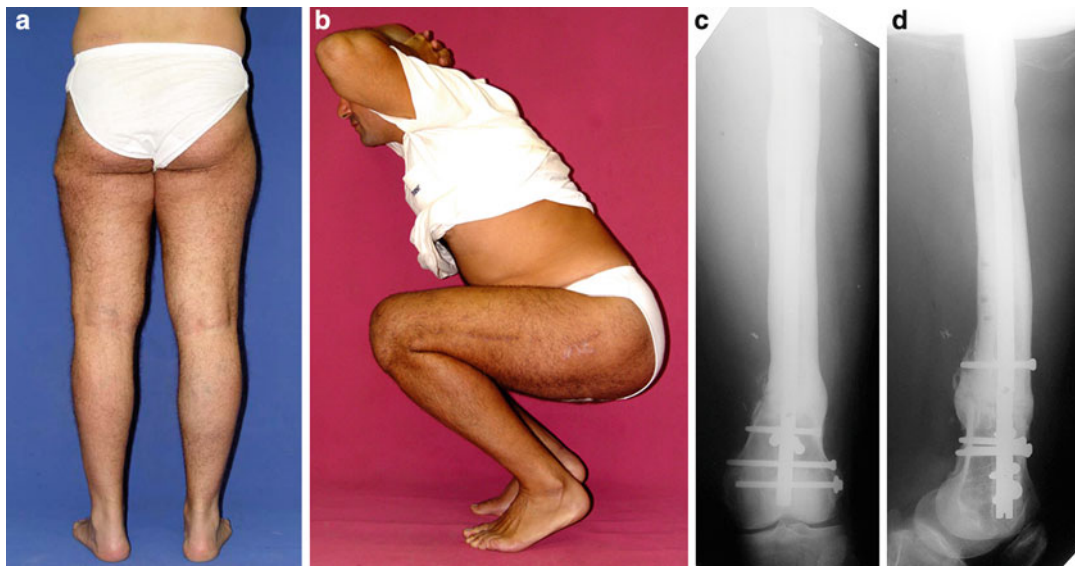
(a) Clinical picture at the end of the treatment. (b) Functional clinical picture. (c) AP X-ray after complete bone healing. (d) Side view X-ray after complete bone healing
